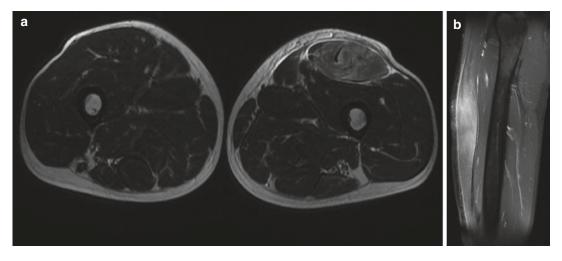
Focal myositis of the left rectus femoris muscle. (a) Axial FS T2-weighted MR image; (b) sagittal FS T2-weighted MR image. There is diffuse increased signal
